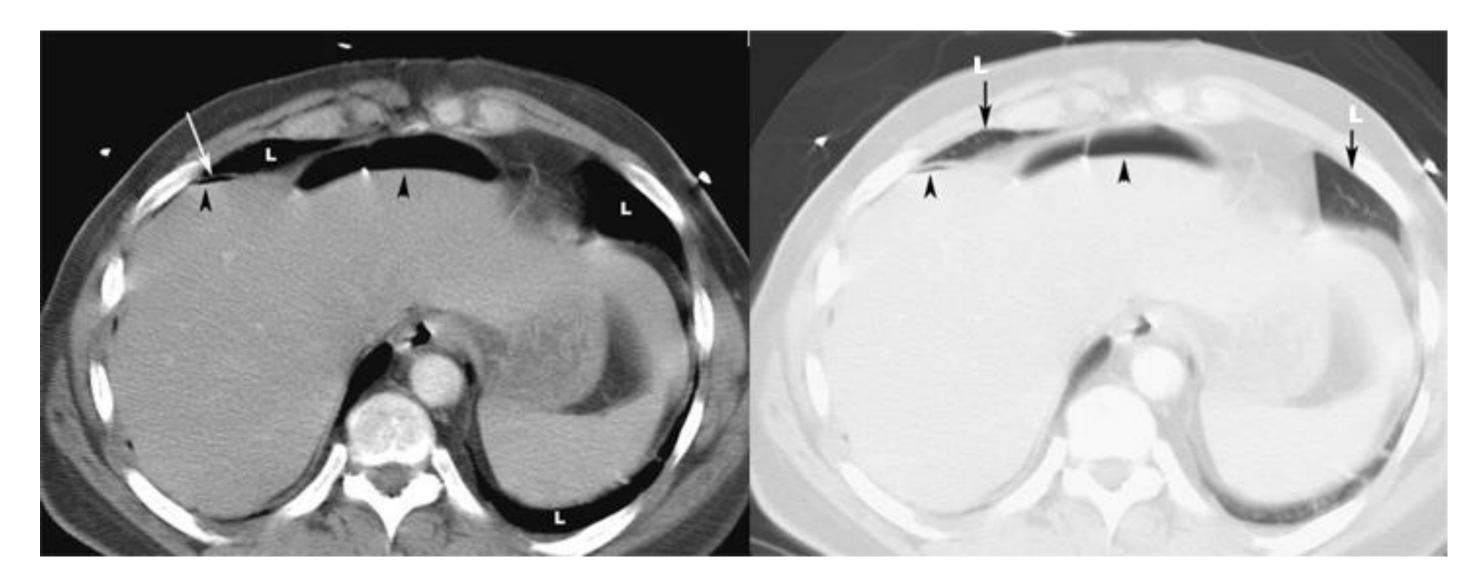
CT scan pneumoperitoneum
